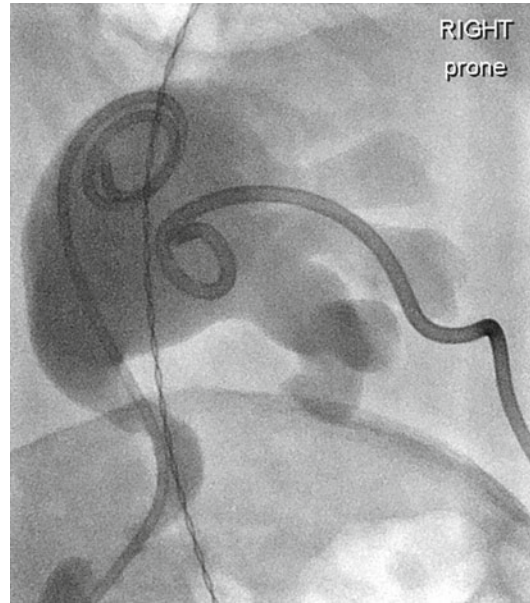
Procedural x-ray showing position of ureteric stent and percutaneous nephrostomy
